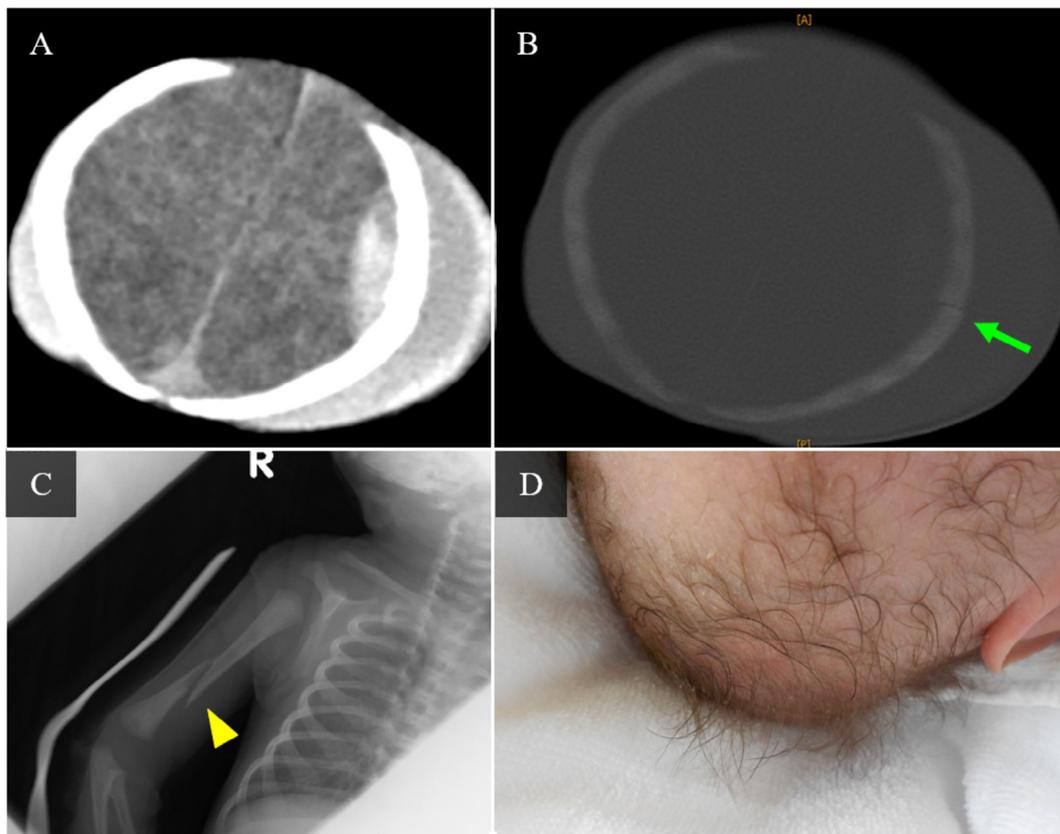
Brain CT at 1 day of age shows cephalohematoma and subdural hematoma (A) and left parietal and right parietal–occipital skull fracture (arrow) (B). Frontal right humerus radiograph (C) at 12 days of age. Note the apparent right humerus fracture (arrow head). Kinky hair of the patient at 28 day of age (D).
